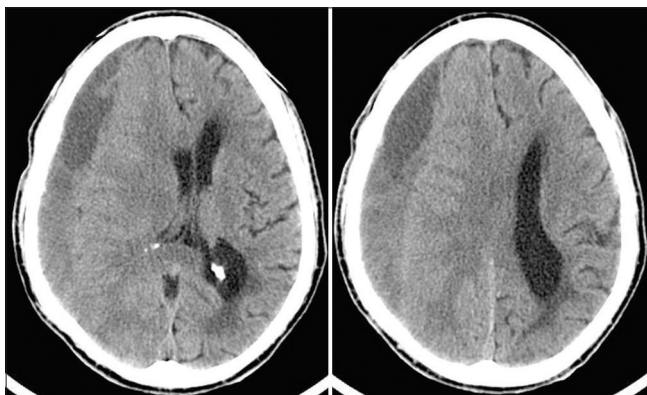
Preoperative cranial CT scan images of the first patient showing right hemispheric chronic subdural hematoma with partial effacement of the right lateral ventricle and midline shift to the left.
